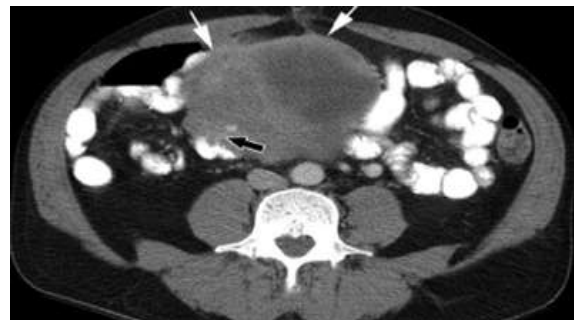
CT image showing gastrointestinal tumor (marked arrows)
